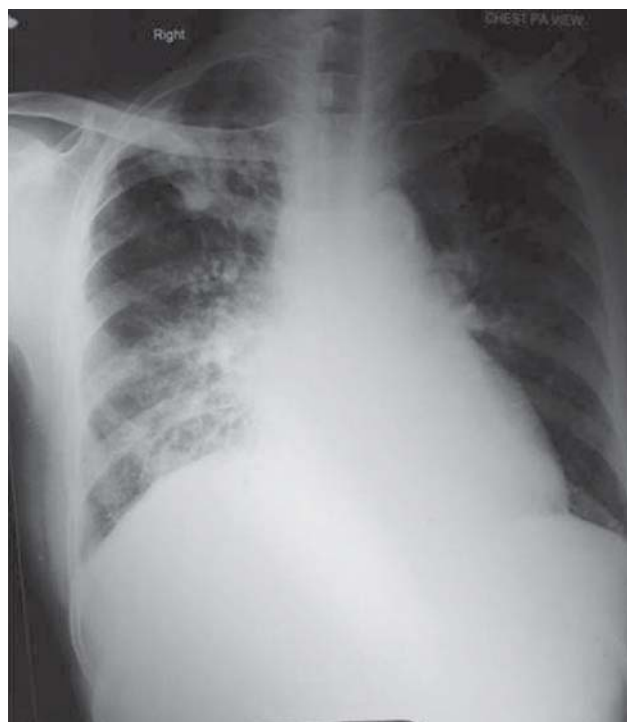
Chest radiograph (postero-anterior view) showing patchy lesions throughout the right lung field.
